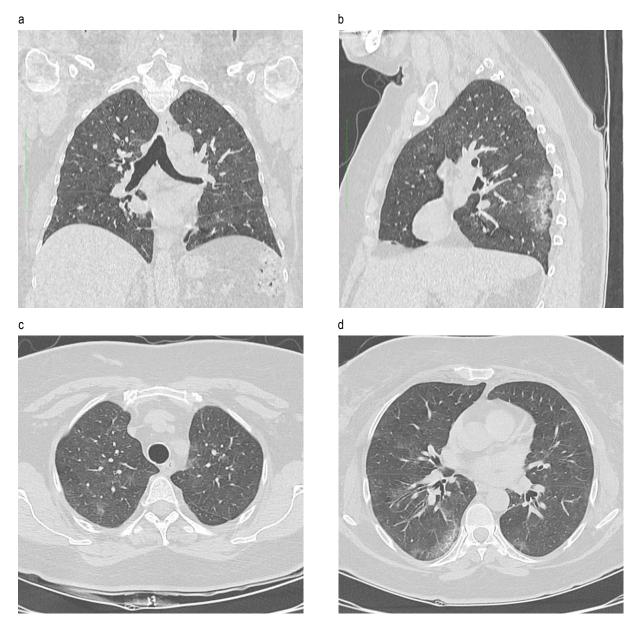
(a–d) Chest CT scans, January 2021. Post-inflammatory lung changes after COVID-19 in form of diffuse ground glass opacity in both lungs and consolidated subpleural compaction in posterior part of right lower lobe.
